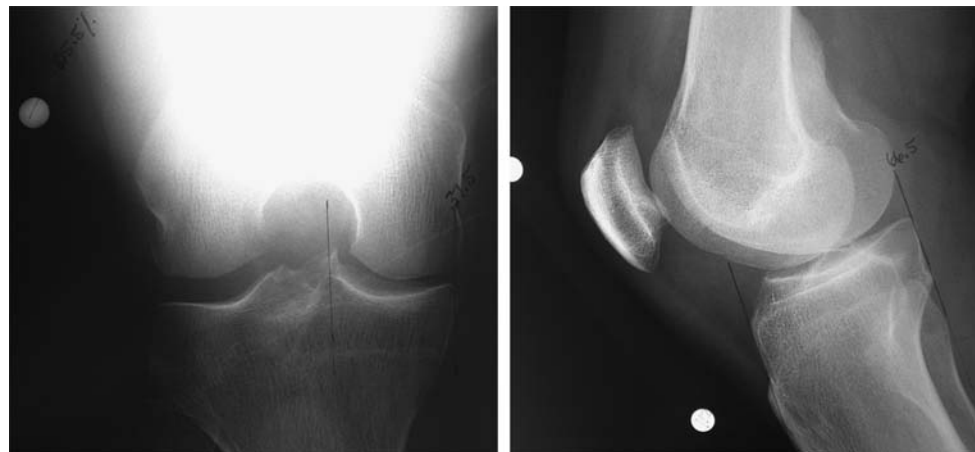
Graft sizing on anteroposterior and lateral radiographs.
